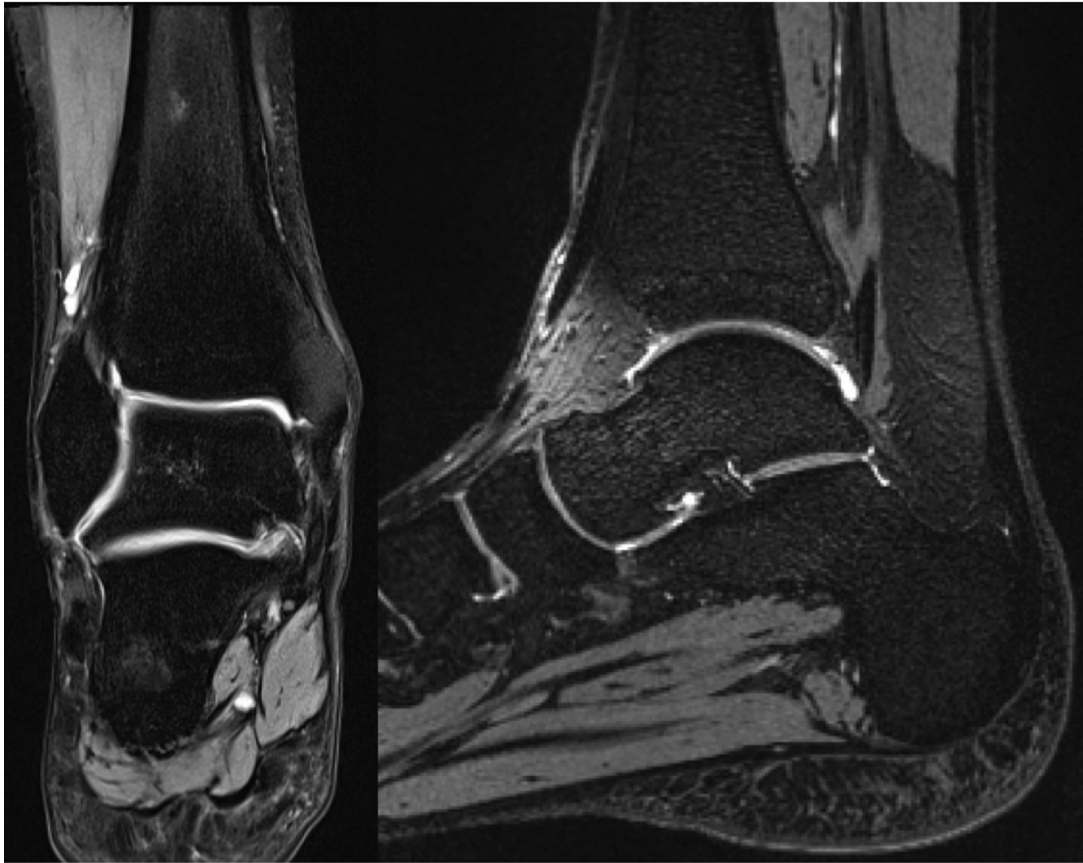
Unremarkable MRI (proton density-weighted with fat saturation (coronal and sagittal reconstruction)) 71 months after closed reduction and conservative treatment of a Salter Harris IV fracture
